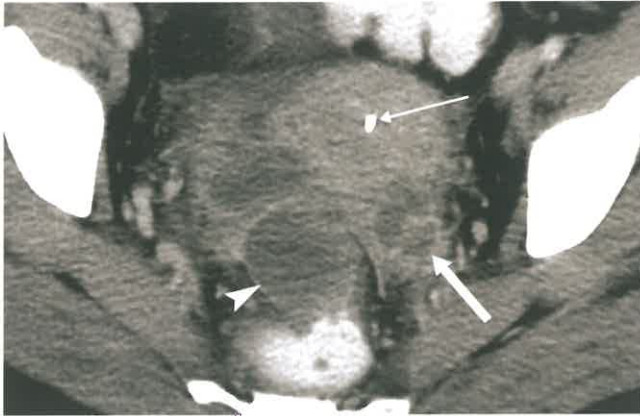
Tuboovarian Abscess. Postcontrast CT in a patient with fever, pelvic pain, and vaginal discharge shows a complex fluid collection enveloping the ovary (*fat arrow*), dilated fallopian tube (*arrowhead*), and uterus containing an IUD (intrauterine device) (*skinny arrow*). Note the extension of edema and inflammation into pelvic fat and the poor margination of involved organs. These are classic findings of tuboovarian abscess.
